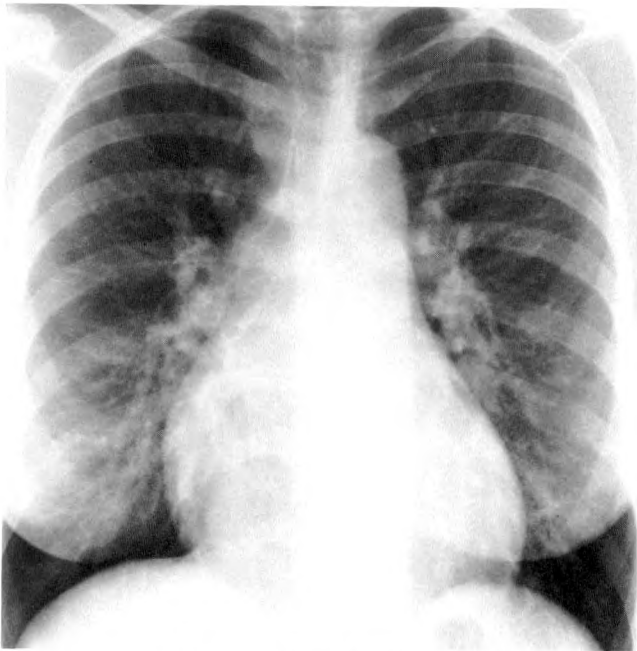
Case 1: 23-year-old woman presented with heart murmur, decreased exercise tolerance, and chronic right leg swelling. Posteroanterior chest radiograph.
